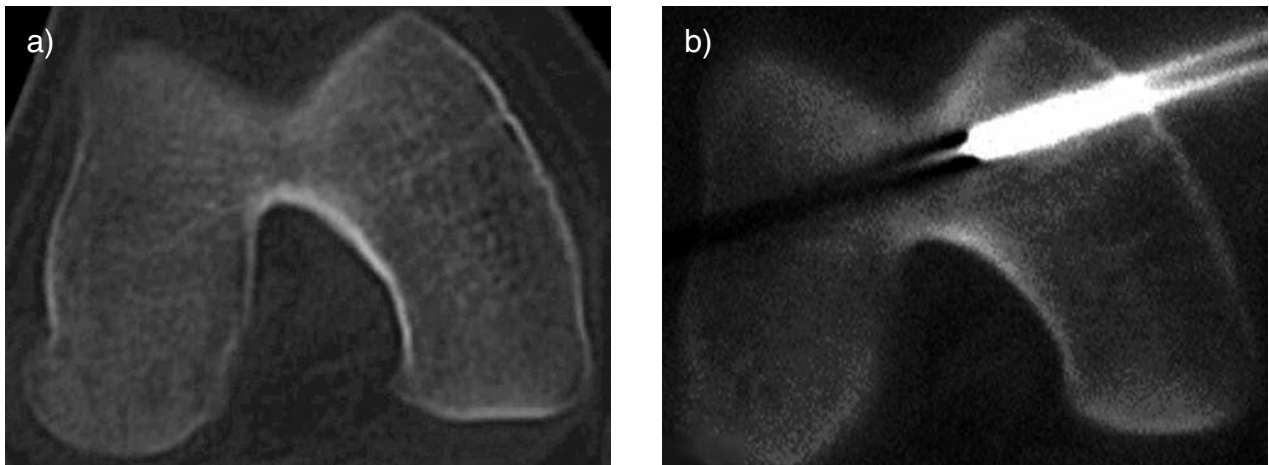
16-MDCT shows normal bone density and trabeculation, without evidence of the lesion (a). A CT-guided biopsy, was performed after 18 days from MRI (b)
